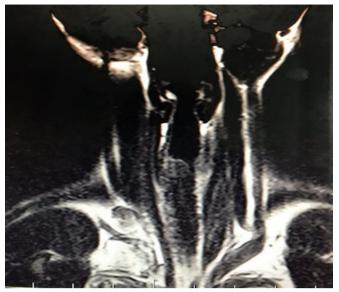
MR image of Case. The mass in the tracheal lumen, caudal to the larynx in the coronal plane is indicated by the arrow.
